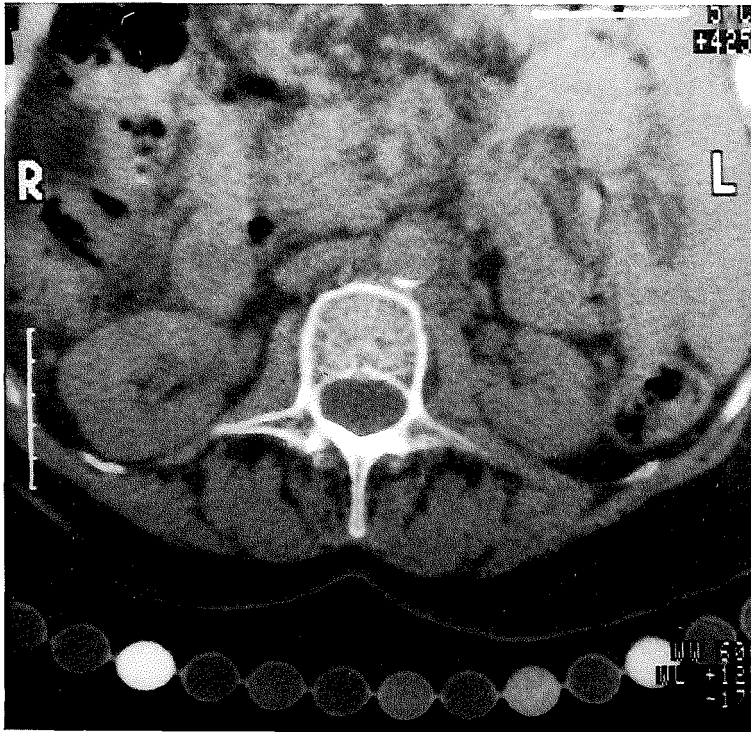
CT image of patient case study.*
